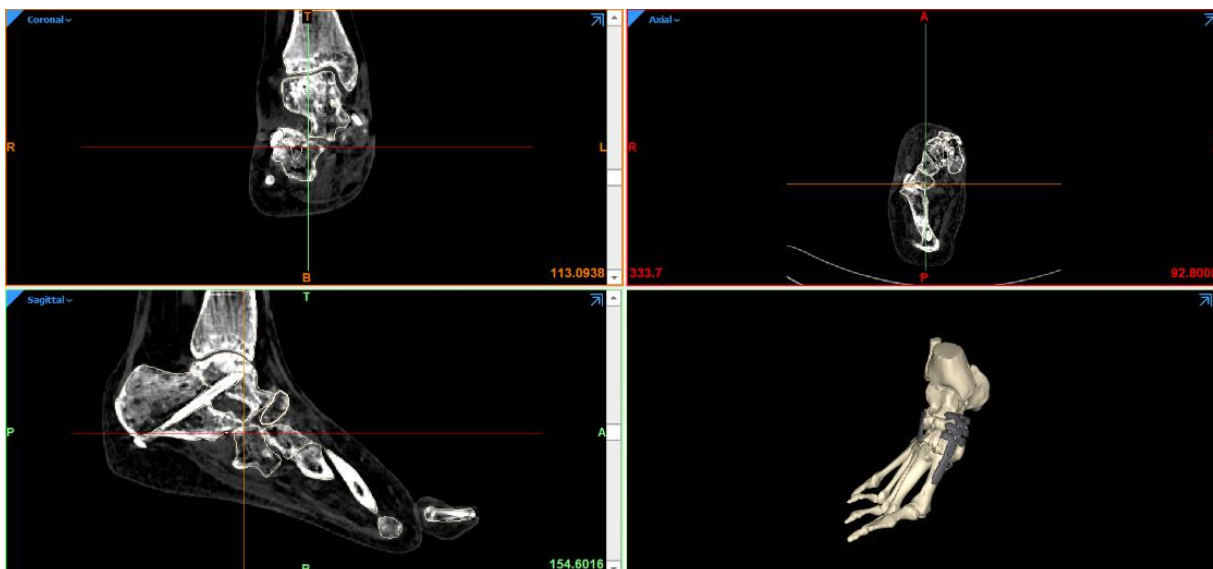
CT data of the supinely aligned preoperative foot of case B. Coronal (top left), Axial (top right) and Sagittal (bottom left) multiplanar reconstructed (MPR) views of CT data. The 3D model constructed from CT data is shown in the bottom right corner*
